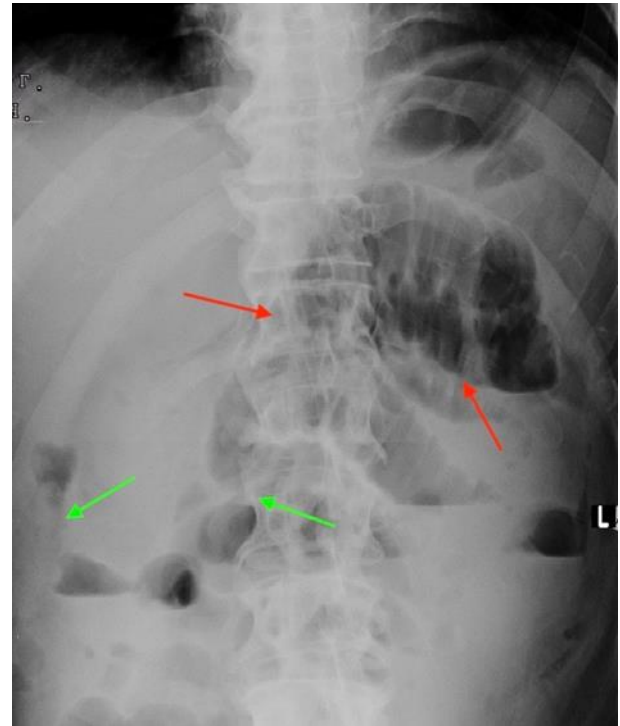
Erect plain abdominal X-ray on admission confirming acute small bowel obstruction. Dilated small bowel loops with wall and mucosal thickening (valvulae conniventes), and air-fluid levels (red arrows). Transition zone with paucity of gas distally (green arrows).
